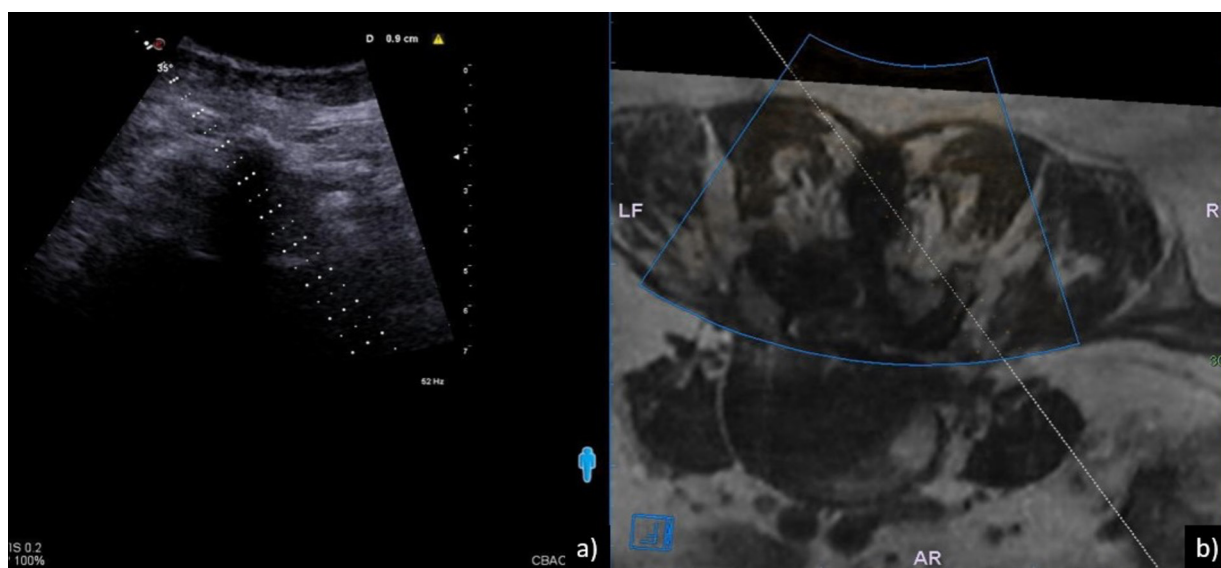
Fusion MRI-US image-guided lumbar spine injection. In (a), the bony landmark of the spinou process is visualizaed to register the needle; in (b), the MRI images are superimposed and the needle trajectory (*white line*) is displayed.
